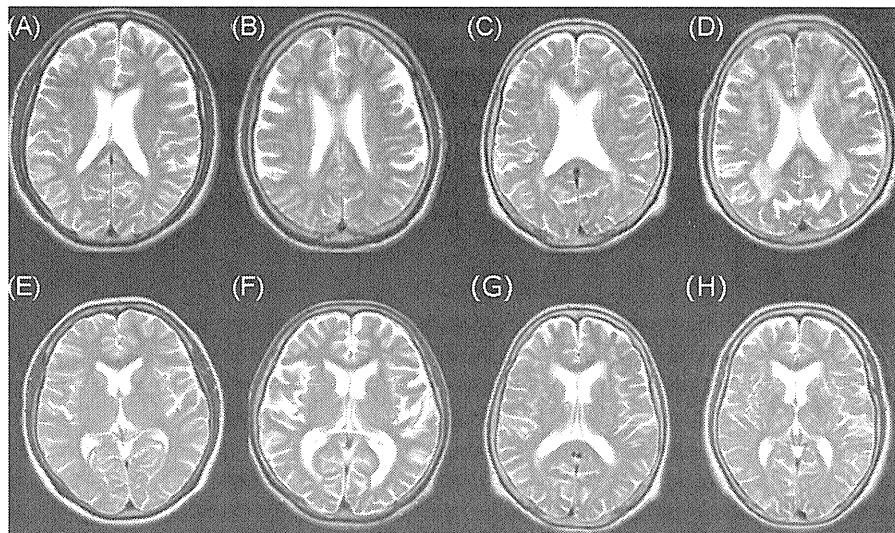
(A–H) Examples of rating scores 0, 1, 2, and 3 on cerebral T2-weighted imaging. Upper column: definitions of rating scores for white matter lesions: 0, no lesion (A); 1, focal lesions (B); 2, beginning confluence of lesions (C); 3, diffuse lesions in all over white matters (D). Lower column: definitions of rating scores for basal ganglia and thalami: 0, no lesion (E); 1, focal lesions (F); 2, >1 focal lesions (G), and 3, confluent lesions (H).
